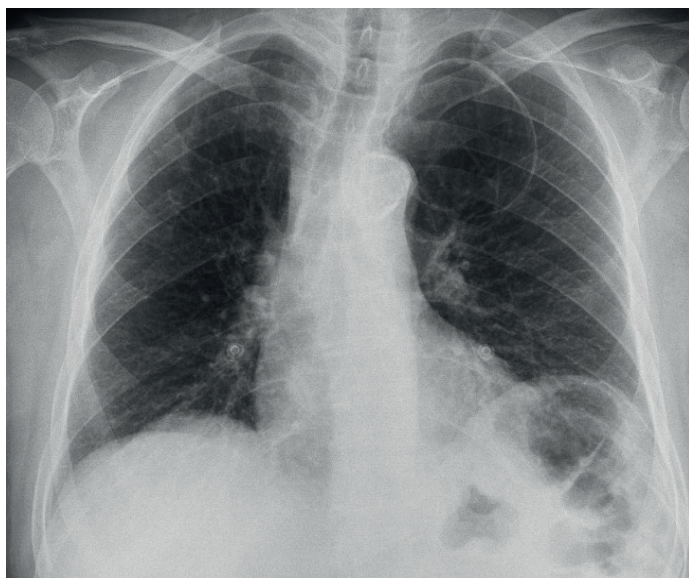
Giant cyst at the top of chest x-ray
